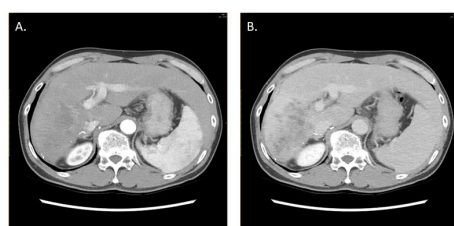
Follow-up liver dynamic CT scan after 2 cycles of atezolizumab and bevacizumab. Imaging shows decreased tumor size with enhancement on arterial phase (A) and washout on portal phase (B).
